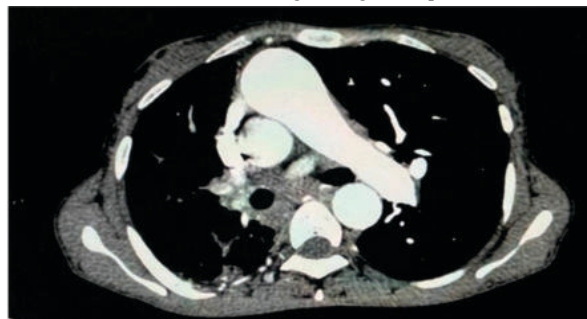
(A): CT-Pulmonary Angiogram
